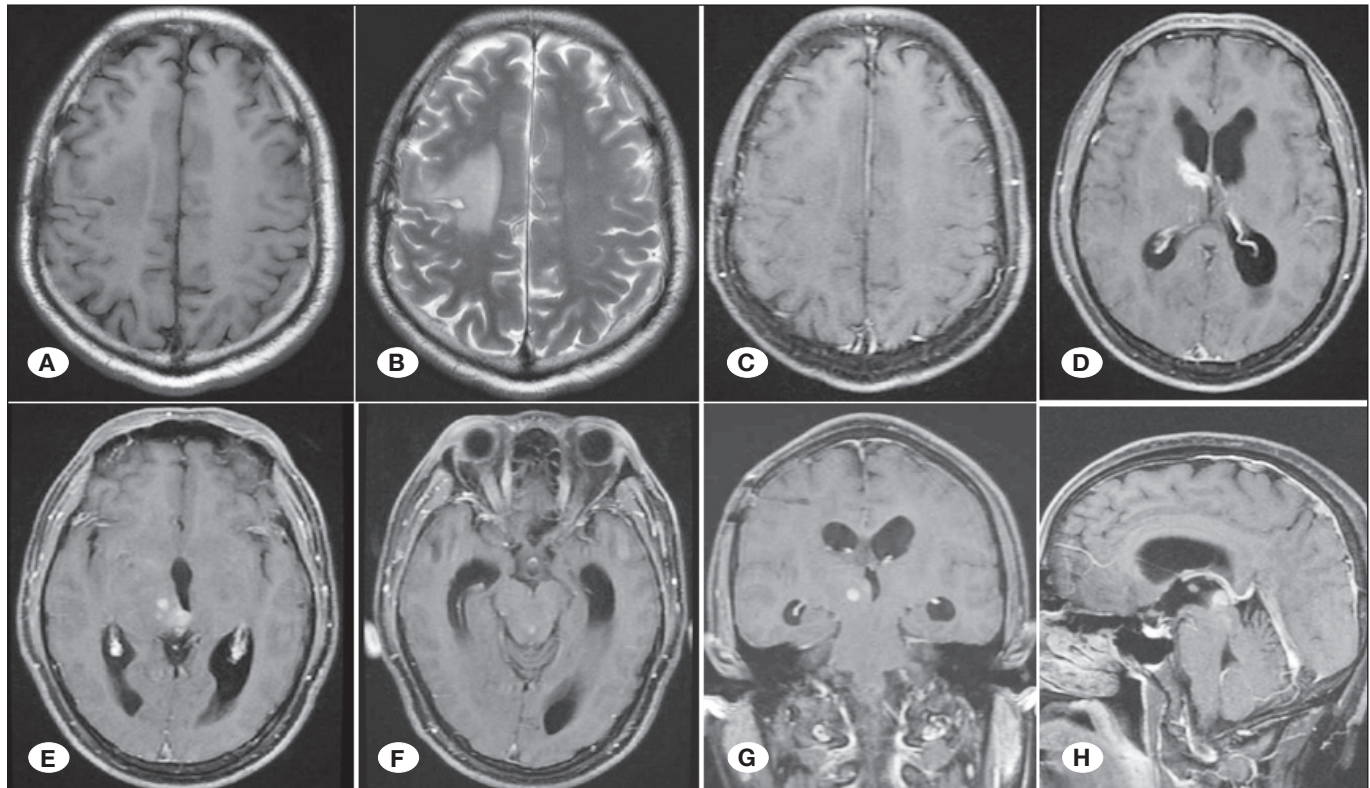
Axial A) T1W; B) T2W; and C-H) contrast enhanced T1W in axial, coronal and sagittal sections. There was no significant change in the original right-side lesions. MRI indicated multiple space-occupying lesions in the posterior third ventricle, right basal ganglia, and subependymal area, with obstructive hydrocephalus.
